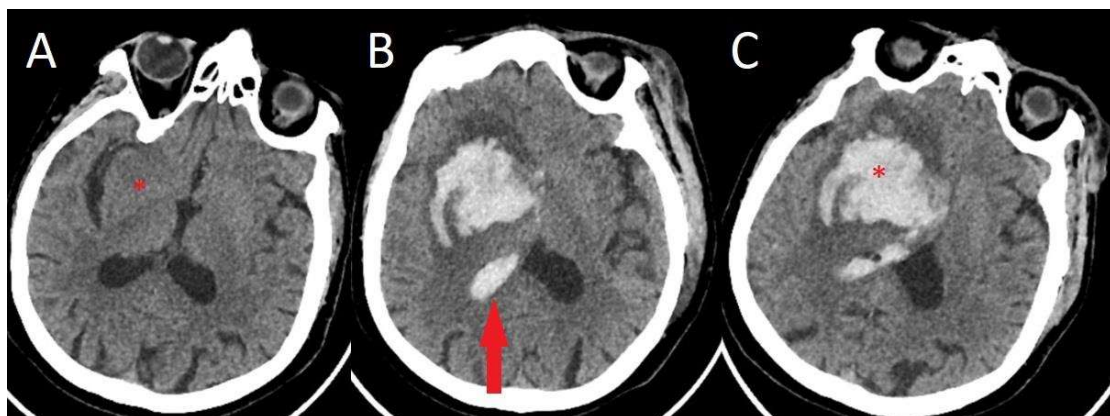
Reassessment 24 and 48 hours after the onset of an ischemic stroke. Image A. Ischemic stroke at the level of the basal ganglia and internal capsule on the right side (*); Image B. The worsening of the symptoms led to a second CT examination, 24 hours after the onset of the symptoms, which revealed the significant dimensional hemorrhagic transformation associated with a midline shift contralaterally by 12 mm and ventricular effusion at the level of the occipital horn of the left ventricle (arrow). Image C. The evolution of the hematoma 48 hours after the onset of ischemic symptoms shows minimal dimensional evolution of the hematoma.
